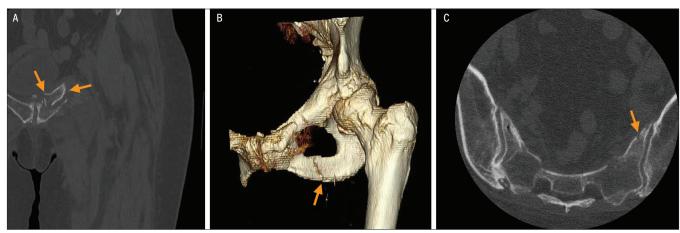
(A) Coronal computed tomography (CT) of the left hip demonstrating a comminuted, mildly displaced fracture of the left superior pubic ramus extending into the pubic symphysis; (B) 3-D CT of the left hip demonstrating a minimally displaced transverse fracture of the left inferior pubic ramus, and (C) axial CT of the lumbar spine at the level of the sacroiliac joint demonstrating a subtle nondisplaced fracture of the left sacral ala, likely extending into the left sacroiliac joint.
